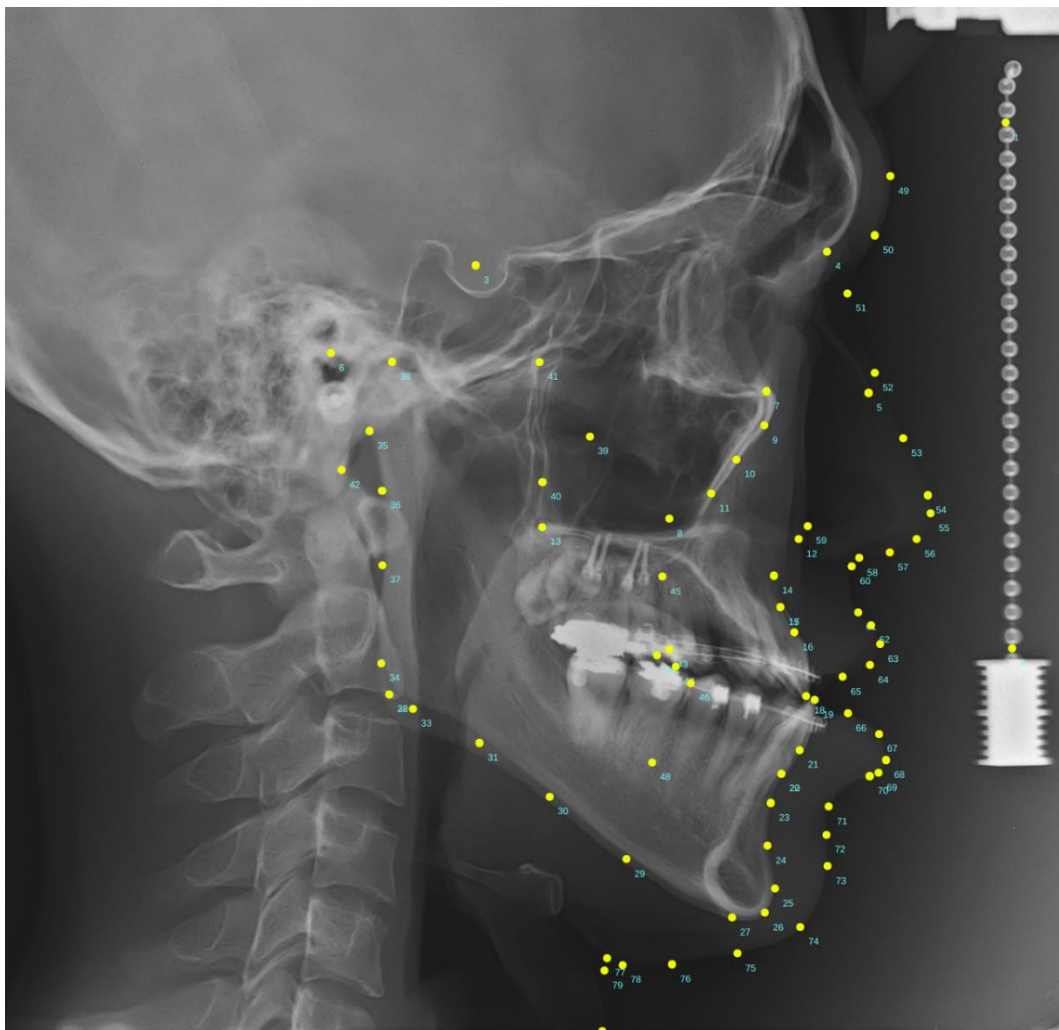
An image composed of the radiograph with the cephalometric landmarks used in this study. (Yellow dots) Landmark-specific information are summarized in Table 1. For the hard tissue landmarks, upper-case letters were used. For the soft tissue landmarks, lower-case letters were used.
